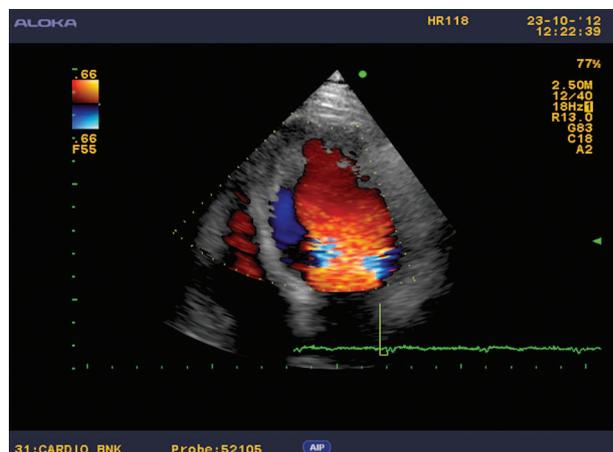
Patient's echocardiographic images
